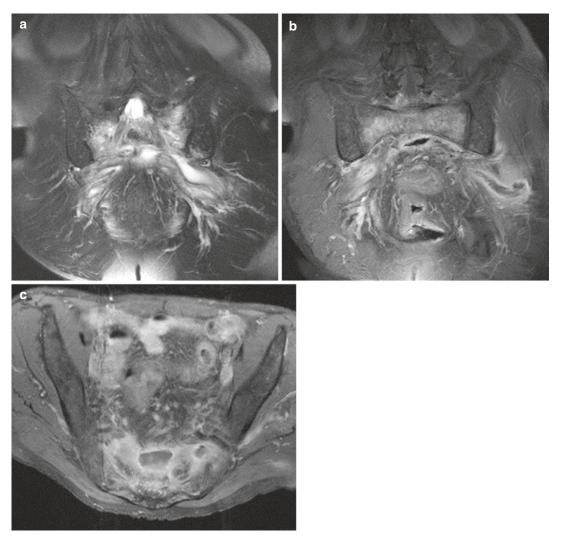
(a, b) Sacral osteomyelitis and multiple pelvic abscesses. (a) Oblique FS coronal T2-weighted MR image; (b) oblique coronal FS T1-WI MR image. (b) Oblique coronal contrast-enhanced FS T1-WI MR image. (c) Axial contrast-enhanced FS T1-WI MR image.
